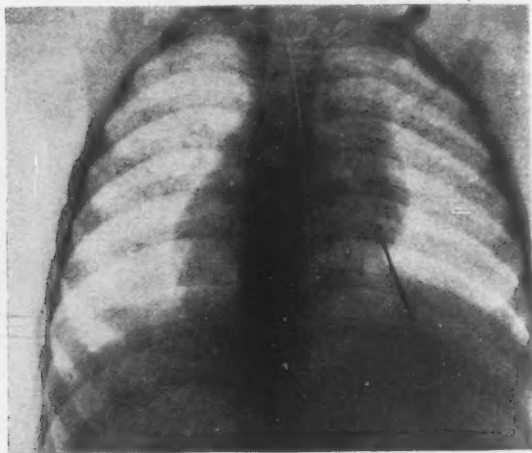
Roentgenogram showing needle deep in the lung of a child aged two and one-half years. The needle had entered a tiny bronchus, the orifice of which was out of sight. Removed by peroral bronchoscopy without anesthesia, general or local. Immediate recovery.
